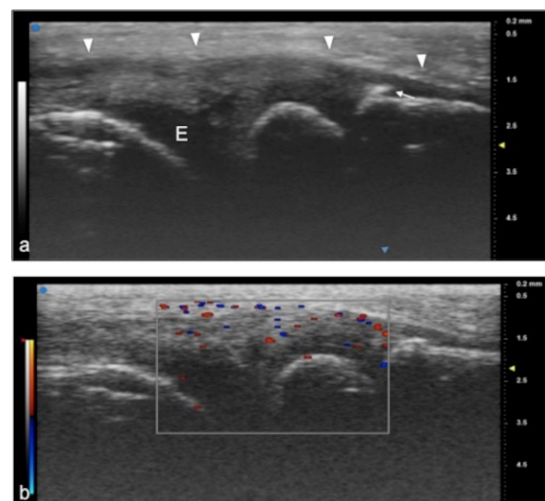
Juvenile idiopathic arthritis. UHFUS gives clear details of pathological findings in pediatric patients with JIA. In (a), articular effusion (E) at the level of wrist and enthesophyte (white arrow). Thickened capsule (arrowheads) in (a) presenting with an increased Doppler signal (white square) in (b).
